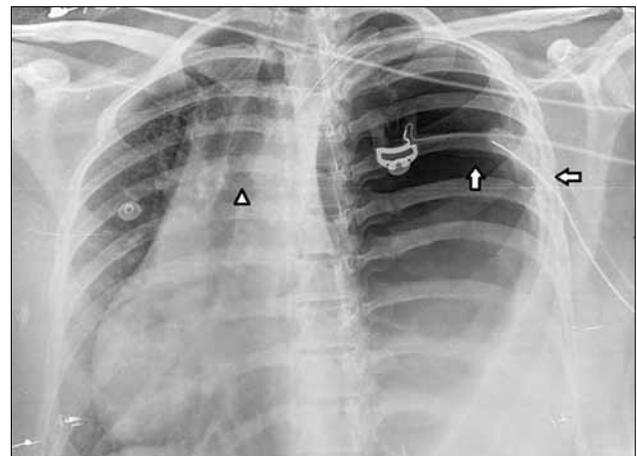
Left tension gastrothorax with left intercostal drain. Chest X-ray of a 28-year-old pregnant female shows herniation of the stomach into the left hemithorax (vertical arrow), with intercostal drain (horizontal arrow) and mediastinal shift to the right side (arrow head).
